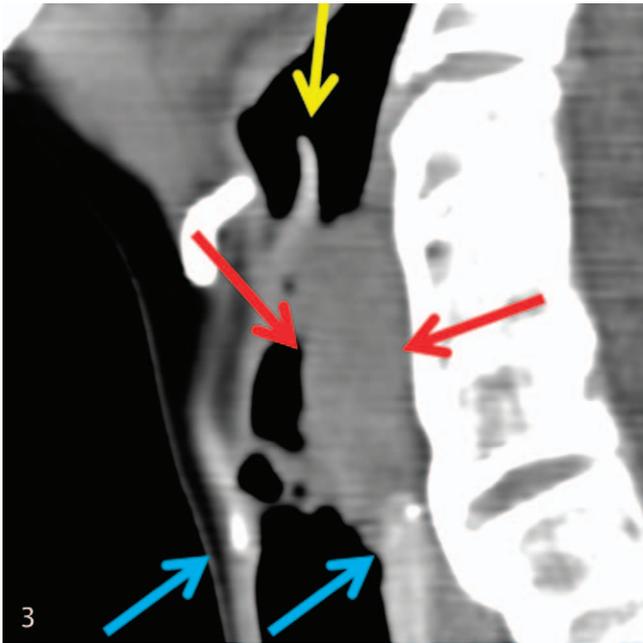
Sagittal multislice computed tomography cross section on the midline of the neck. Corpus alienum (red arrows) in the larynx between glottis (yellow arrow) and cricoid cartilage (blue arrows).
